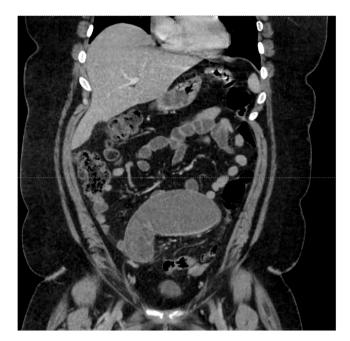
Day 0: CT Abdomen/Pelvis ordered by primary care physician showed tubular heterogenous fluid filled structure extending from pelvis to lower abdomen, measuring $7.1 \text{cm} \times 20 \text{cm}$, with blind ending.
